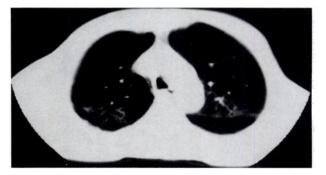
Chest CT scan two months after cessation of amiodarone therapy, showing nearly complete resolution of right upper lobe infiltrate.
